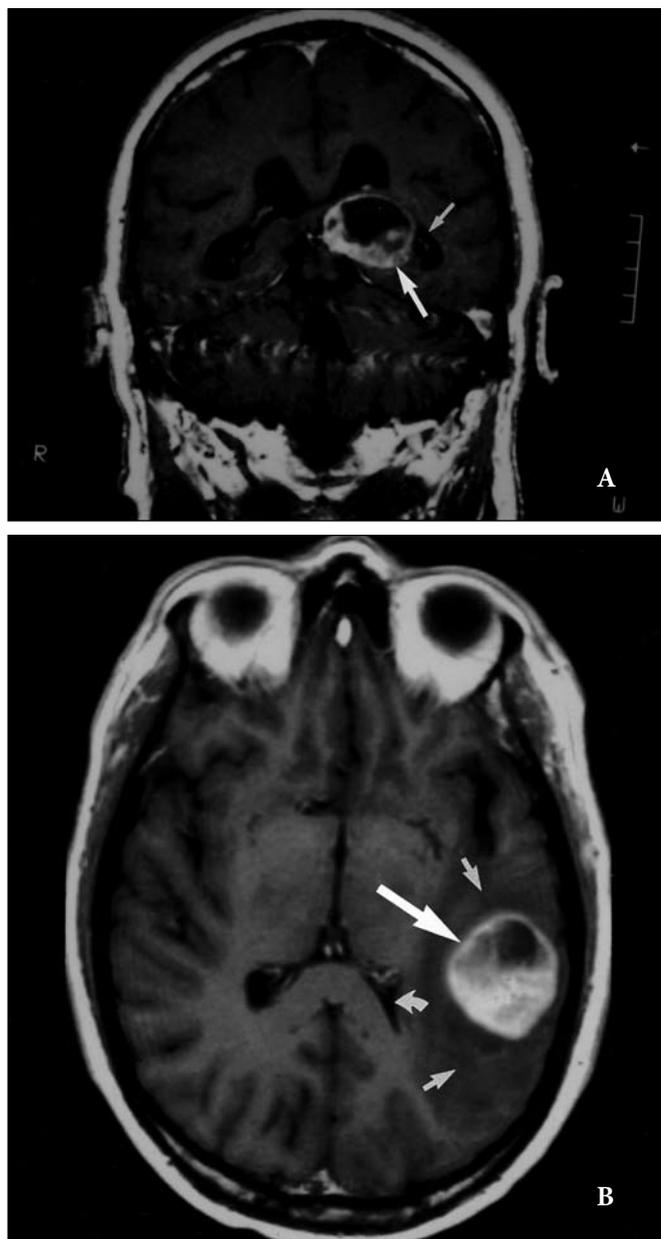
Radiological features of malignant glioneuronal tumors: A: Contrast-enhanced coronal T1-weighted (TR/TE=600/15) MR image depicts a predominantly peripheral enhancement and a centrally necrotic mass (large arrow) that partially expands the lateral ventricle (small arrow). This image is an example of the discrete type appearance of in Category 1 tumors (Patient #11). B: Contrast-enhanced axial T1-weighted (TR/TE=600/15) MR image shows a heterogeneously enhancing mass predominantly in the posterior right temporal lobe (large arrow). Moderate concurrent vasogenic edema is present (small arrows), as is partial effacement of the left lateral ventricle (curved arrow). This is a typical example of the radiological appearance of Category 3 tumors.
